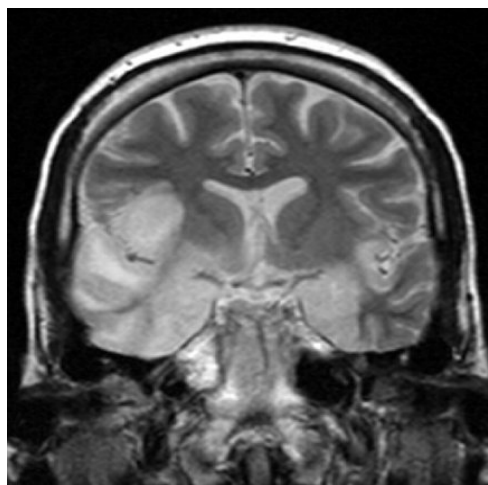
(MRI) Arrow shows T2 hyperintensity and lesion in Temporal Lobe
